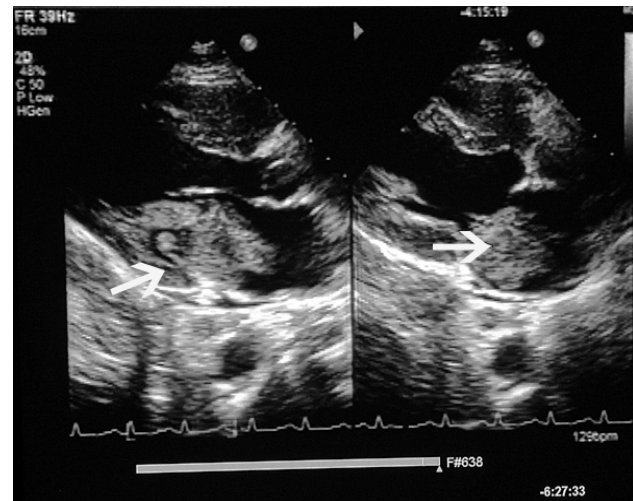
Echocardiogram showing a large tumor with central necrosis protruding through the mitral valve, towards the left ventricle.
